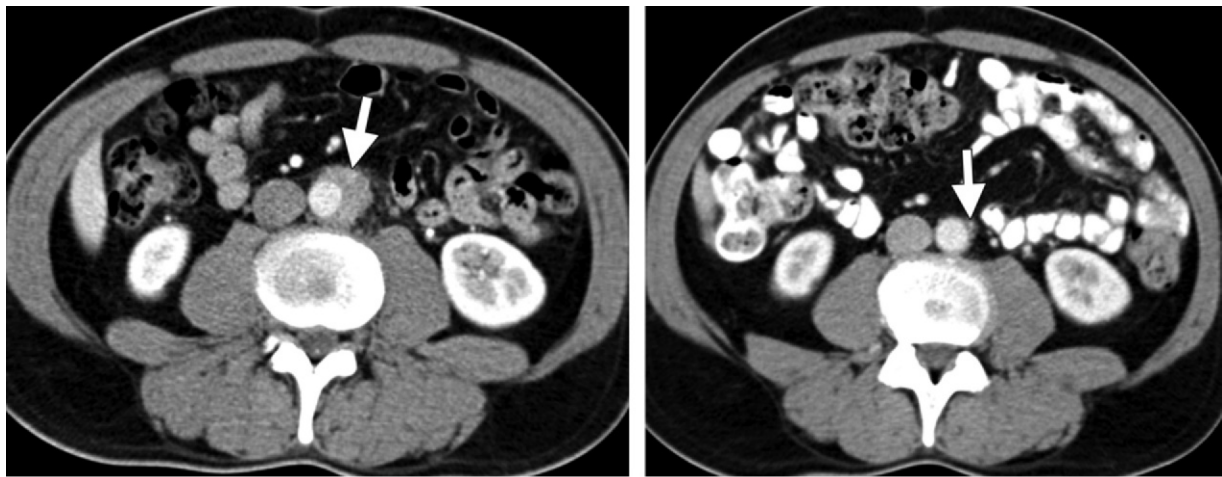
Idiopathic RPF in a 53-year-old man with constitutional symptoms. (a) Axial CT image obtained 60 seconds after contrast material administration shows a retroperitoneal paraaortic mass (arrow) without ureteral entrapment. The presumptive diagnosis was idiopathic RPF. Steroid treatment was instituted. (b) Follow-up CT image 6 months later shows almost complete resolution of the mass (arrow).
